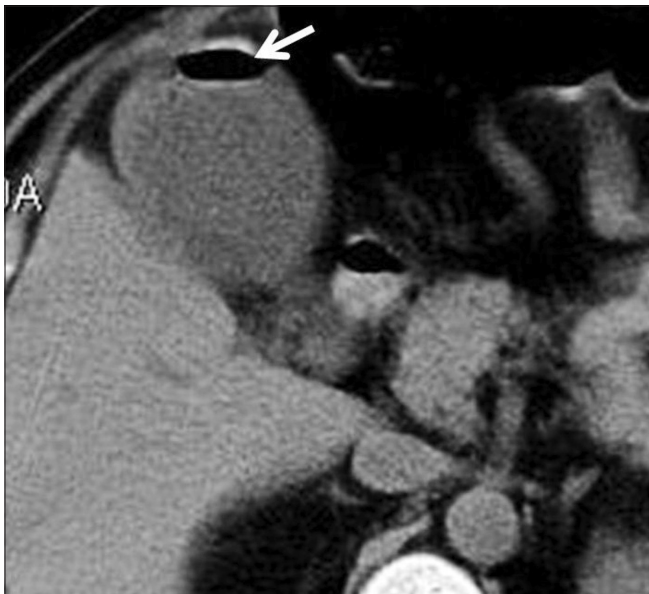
Axial CT scan shows air (arrow) in the gall bladder lumen with an air-fluid level
